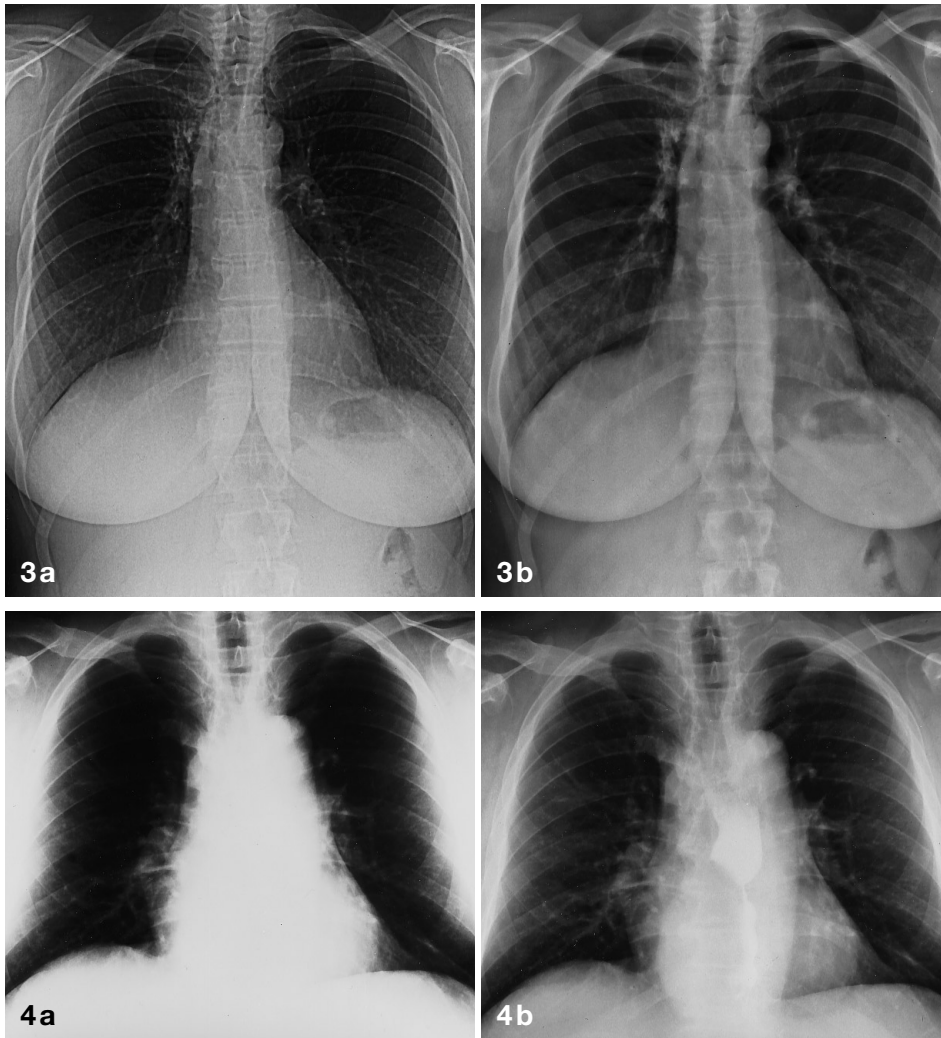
Effect of dynamic range compression in a pa chest radiograph that shows small pulmonary nodules in the retrocardiac region
